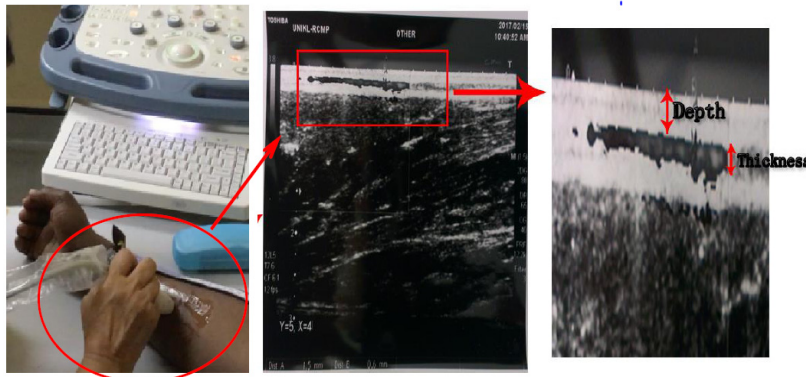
Depth and thickness measurement using an ultrasound linear transducer.
